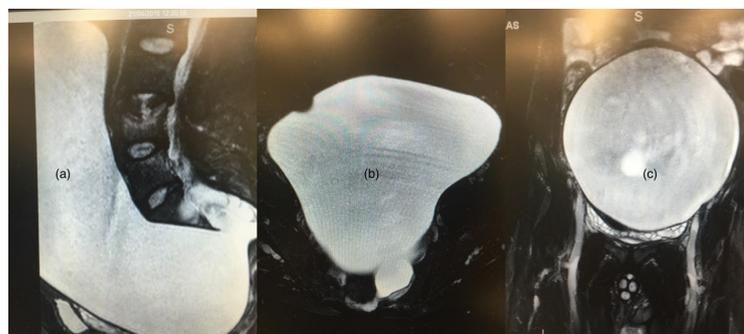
MRI abdomen showing large anterior sacral meningocele in sagittal (a), axial (b) and coronal (c) orientation.
